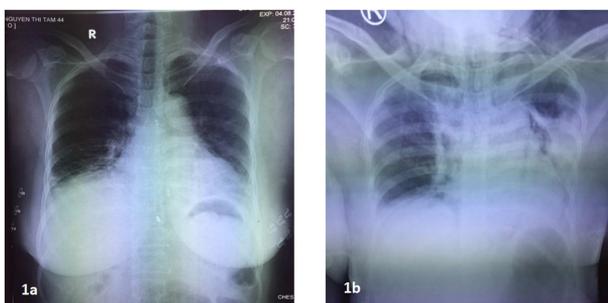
Preoperative anteroposterior chest X-ray showing a rapid change between admittance (1 a) and post-endoscopic time (1 b).
